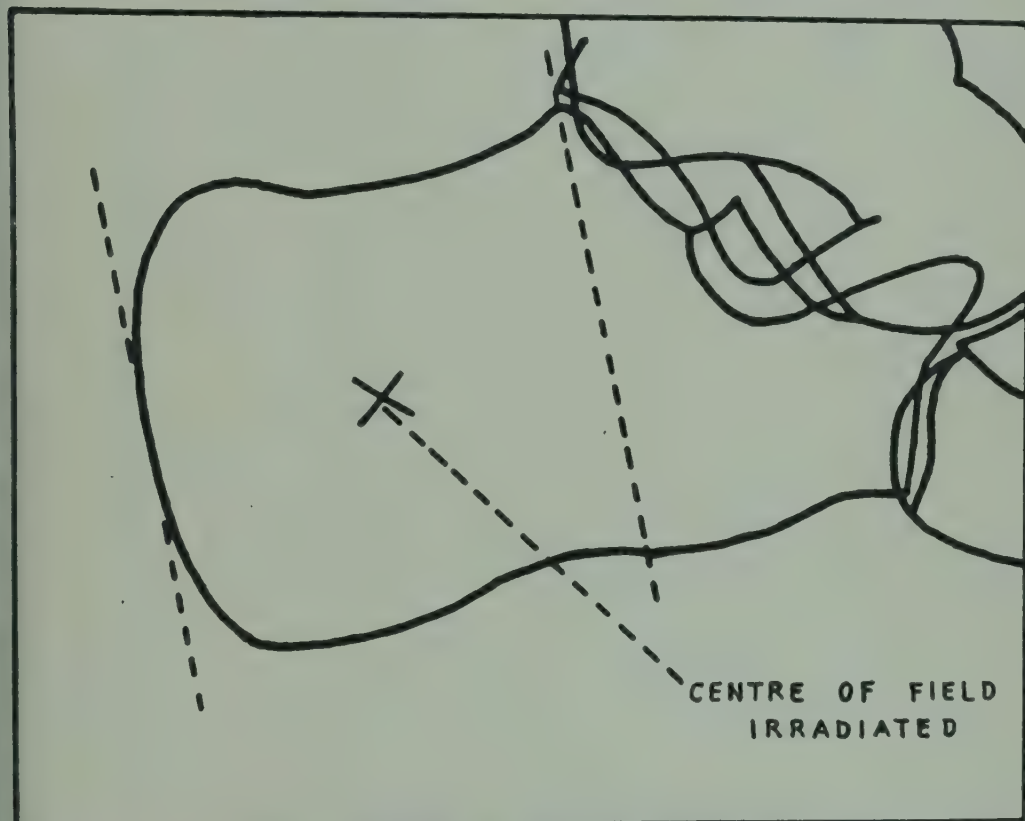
Tracing of a medial radiograph of a calcaneum showing the centre of the field irradiated.
